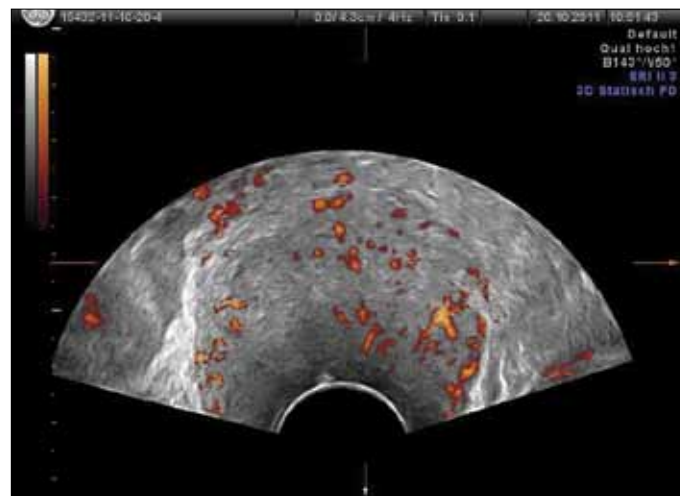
Three-dimensional power Doppler vascularisation of cervical cancer
